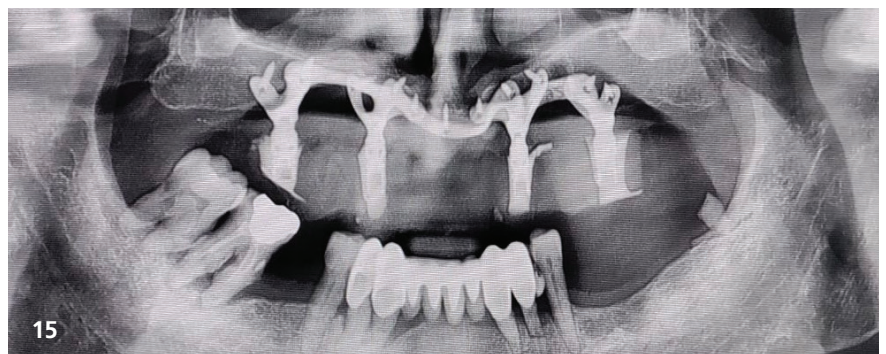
Immediate loading with screw-retained reinforced restoration. Fig. 15: Panoramic radiograph immediately after implantation. Fig. 16: CBCT post-implantation: the intimate contact between implant and bone is clearly visible.
